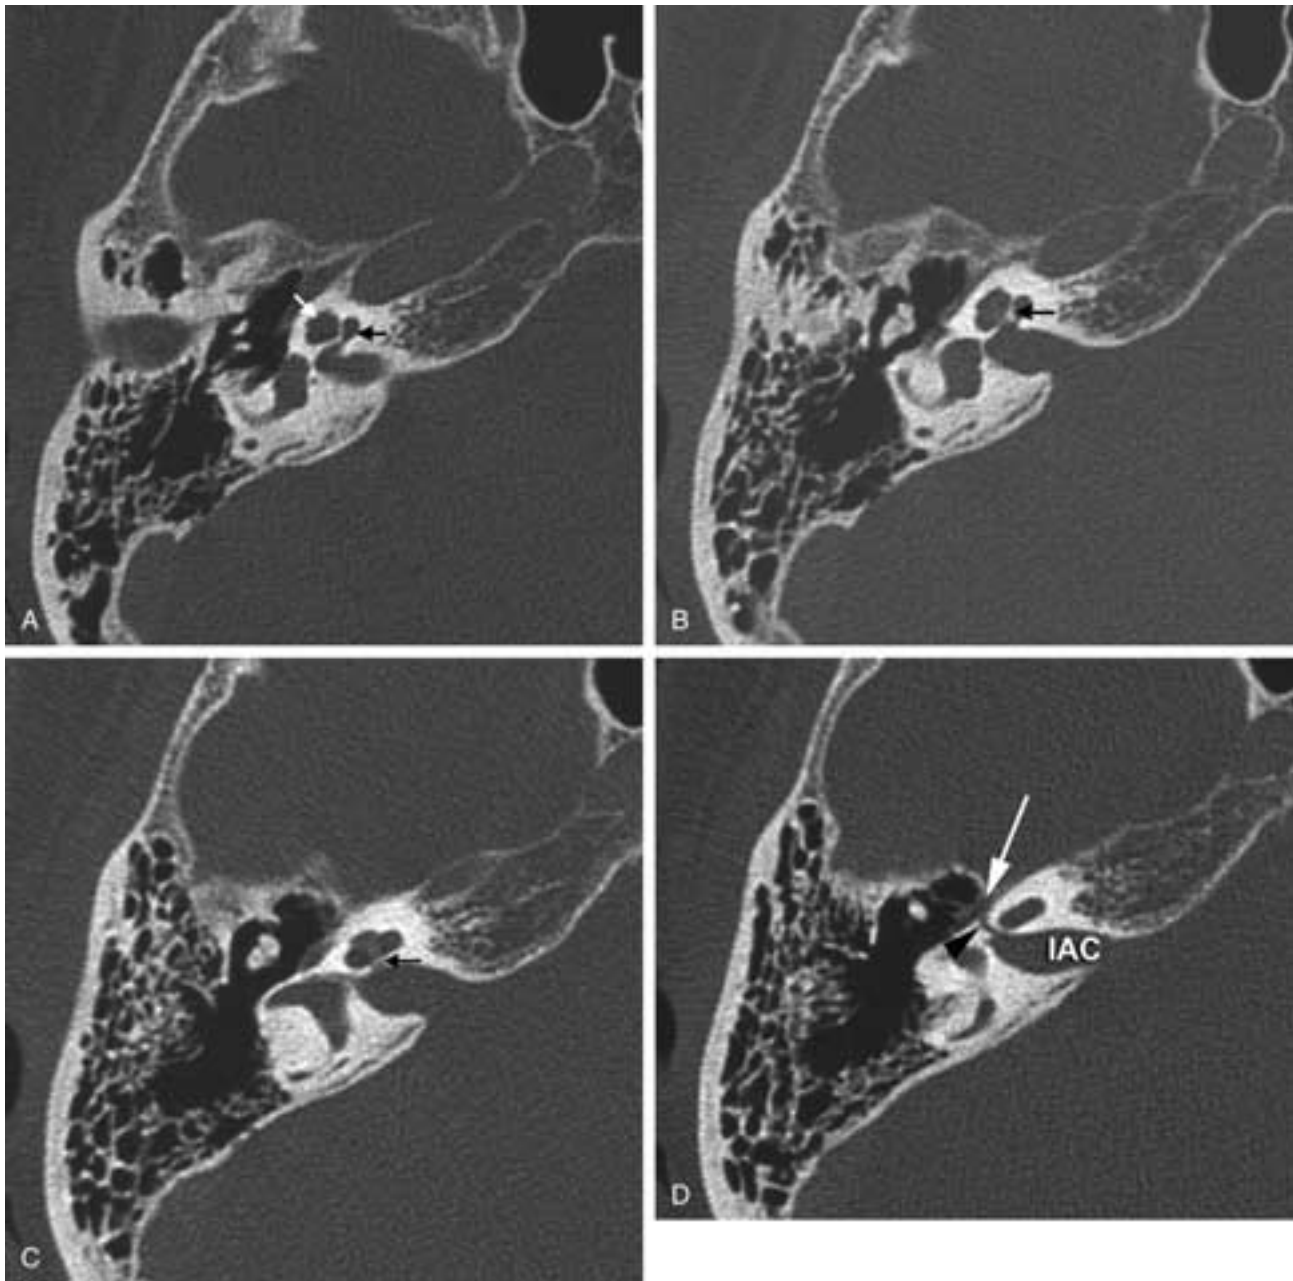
Normal cochlea/modiolus and facial nerve. A to C, Three contiguous 0.5 mm axial CT images through the cochlea from inferior to superior showing a normal basilar turn (*black arrow* in A), normal second and third turns (*white arrow* in A); normal modiolus (*black arrow* in B), and normal cochlear fossette (*black arrow* in C). D, Axial CT image showing the normal origin of the right facial nerve from the IAC. Labyrinthine segment of the facial nerve canal (*black arrowhead*); geniculate ganglion region of the facial nerve (*white arrow*).
